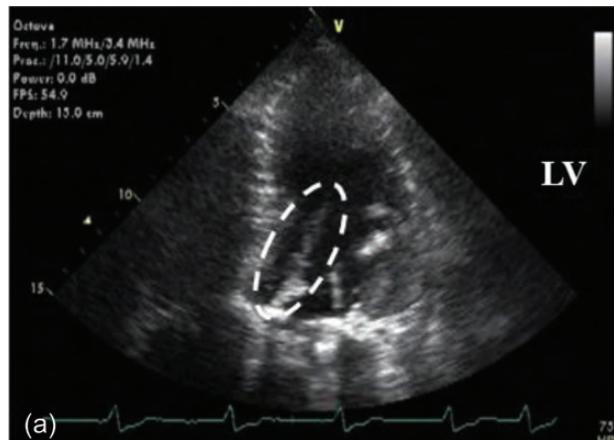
Vegetation and thrombus in the patient's heart. Dotted circles represented the lesions in echocardiogram (a) and autopsy (b).
